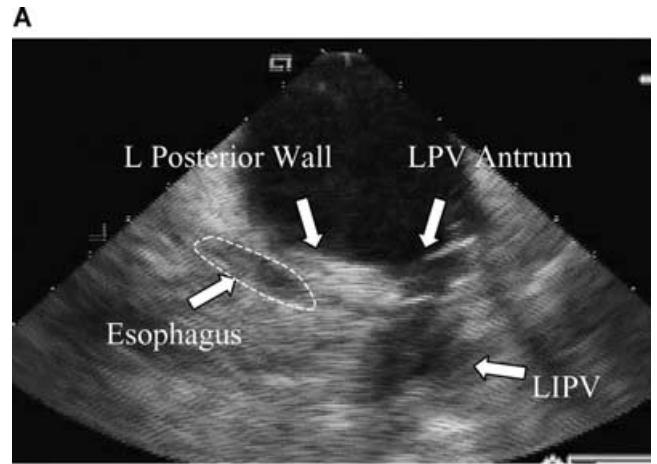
Esophagus at left pulmonary veins in the same patient by ICE and MRI. A: ICE image of the LA with a lasso catheter positioned at the antrum of the left pulmonary venous system. In this view, the esophagus is visible as well in proximity to the left inferior PV (LIPV), the LPV antrum, and the left posterior LA wall. B: Standard axial MR angiographic imaging.
